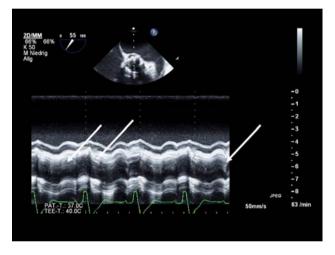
Transoesophageal multiplane echocardiography (m-mode) after TAVI: short axis with one leaflet with pathologic movements (*white arrows*)
